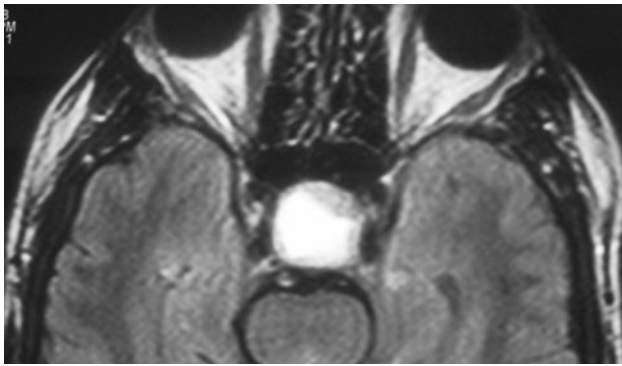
Sagittal MRI brain- showing pituitary tumour (pressing on optic chiasma)
